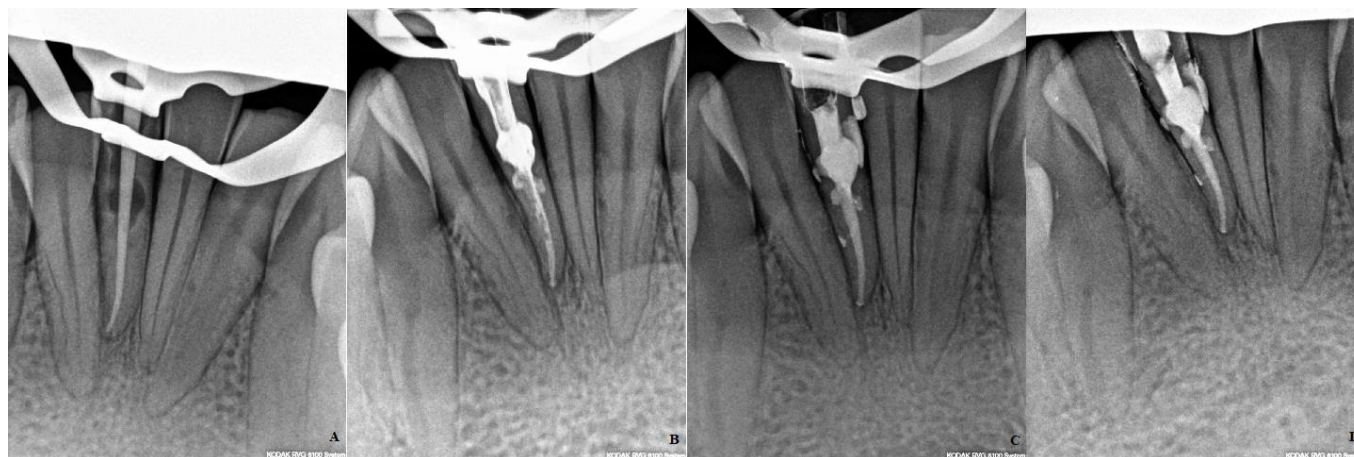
A) gutta-percha cone fit B) down-pack C) backfill D) final radiograph with a provisional restoration.
